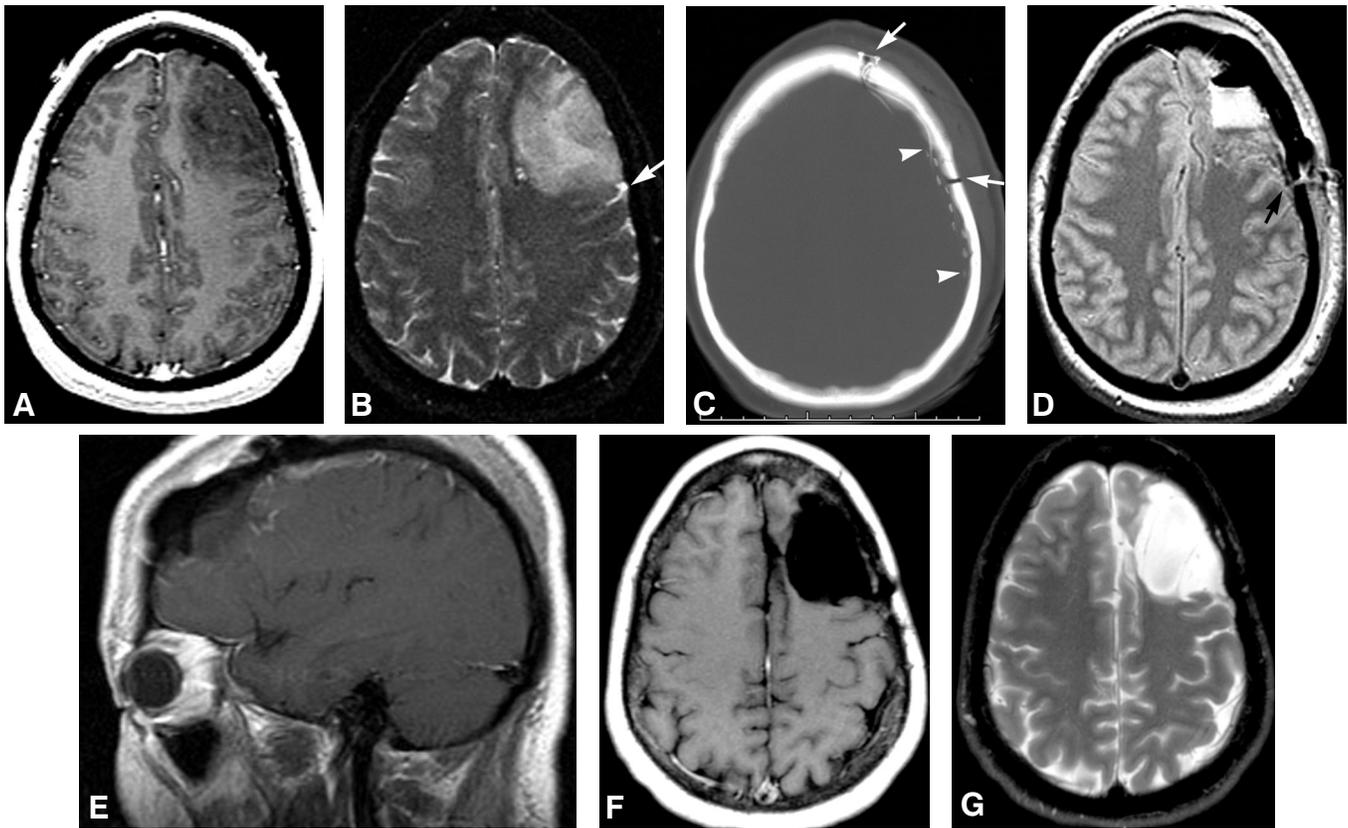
Patient 12. (A) Preoperative axial enhanced T1-weighted MR image shows a low-grade lesion in the left frontal lobe with patchy enhancement near Broca's area and the motor cortex in a 38-year-old woman. (B) Axial T2-weighted MR image shows a sulcus (*arrow*) at the posterior-inferior margin of the tumor. Mapping suggested that this sulcus was the margin between noneloquent and eloquent cortex. Resection proceeded to the sulcal margin. The functional cortex was spared, but the gyrus, which was partially infiltrated with tumor, was removed completely. (C) CT scan shows the position of a single 6 x 8 grid (*arrowheads*) placed over the posterior and inferior aspects of the lesion to map the boundaries of the motor and language cortices. Grids were slipped under the bone edges (*arrows*) to increase the mapping area without increasing the size of the bone flap. Immediate postoperative (D) axial T2-weighted and (E) enhanced T1-weighted sagittal MR images confirm sparing of the sulcal margin (*arrow*) as noted above the frontal operculum. Three-year follow-up enhanced axial (F) T1-weighted and (G) T2-weighted MR images show no tumor recurrence.
